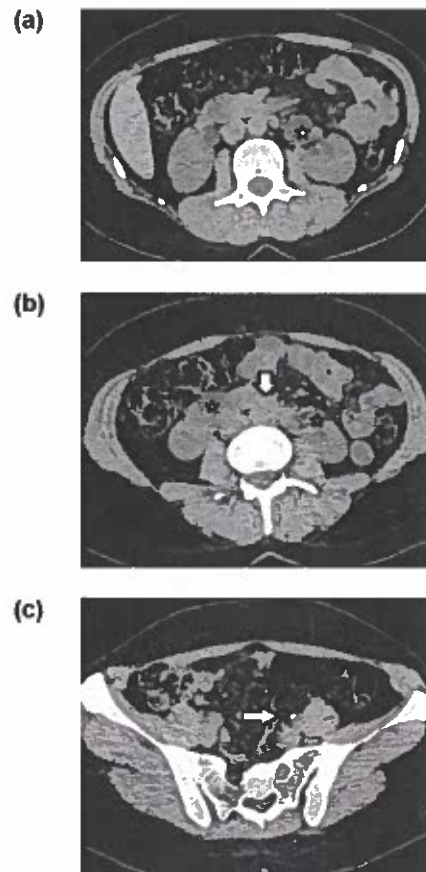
Horseshoe kidney and ureterolithiasis. (a, b) Axial non-enhanced CT images show lower poles of the kidneys fused (arrow), in keeping with a horseshoe kidney. Bilateral hydronephrosis (stars) is also detected, marked on the left side. The cause is a 3x4 mm stone (arrow, c) located in the upper third of the left ureter. A thin halo of soft-tissue density is seen around the calculus (soft-tissue rim sign), a finding that is very specific for the diagnosis of ureterolithiasis.
